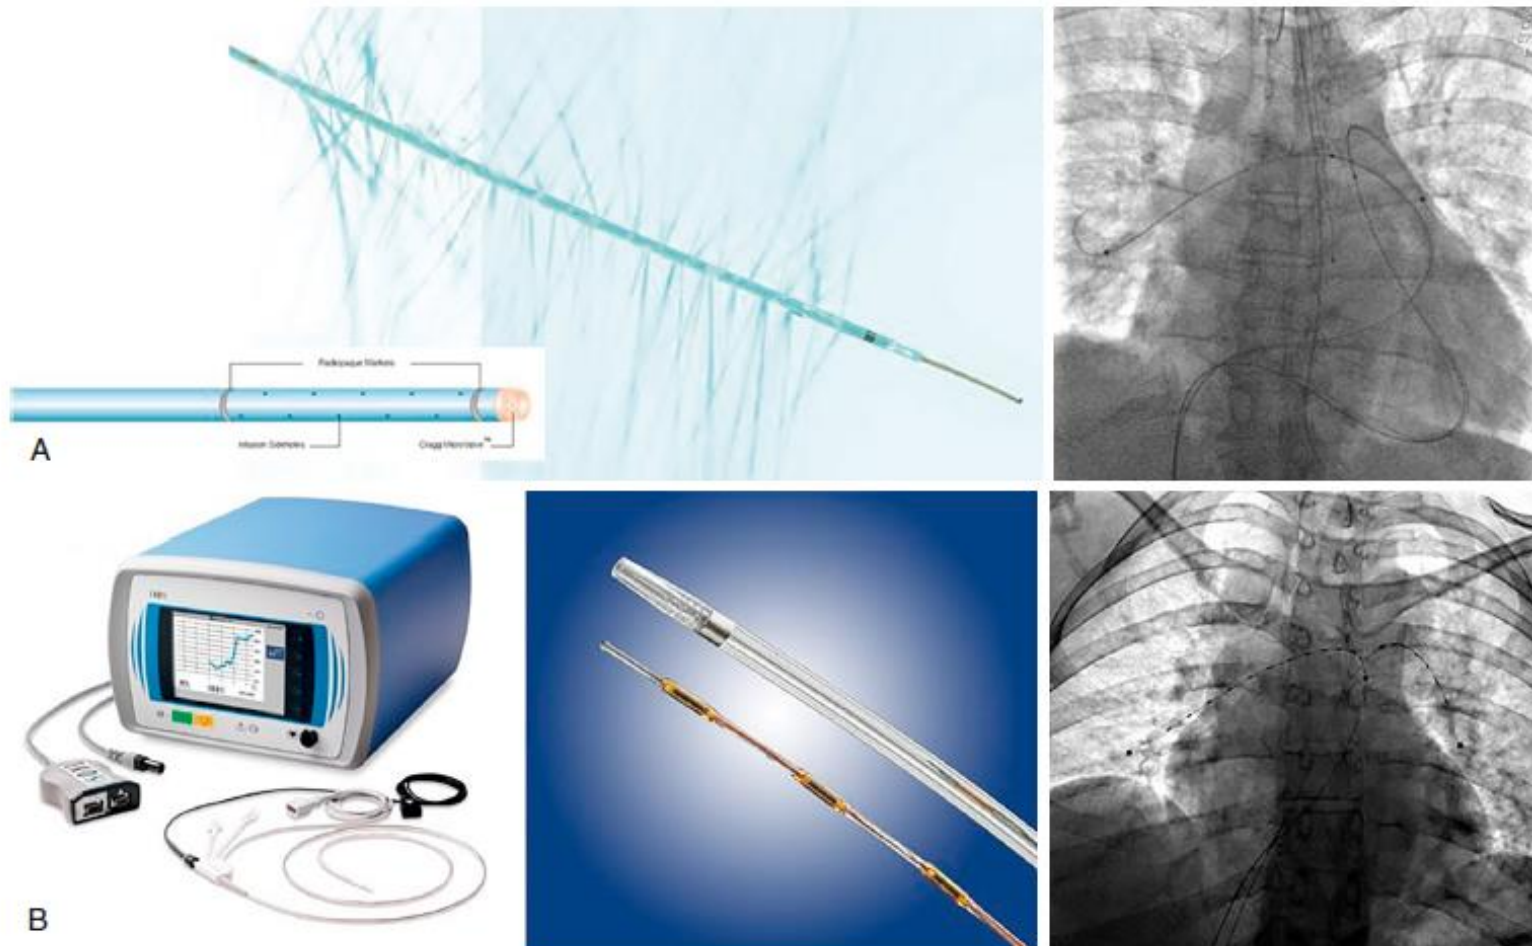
Catheter-Directed Thrombolysis. (A) Five-French standard multi-sidehole catheter. (B) Ultrasound-assisted thrombolysis catheter, EkoSonic (Endovascular System, EKOS Corporation, Bothell, WA). The catheter is composed of a 5.2-F multi-sidehole infusion catheter and a microsonic core wire containing the ultrasound elements.
